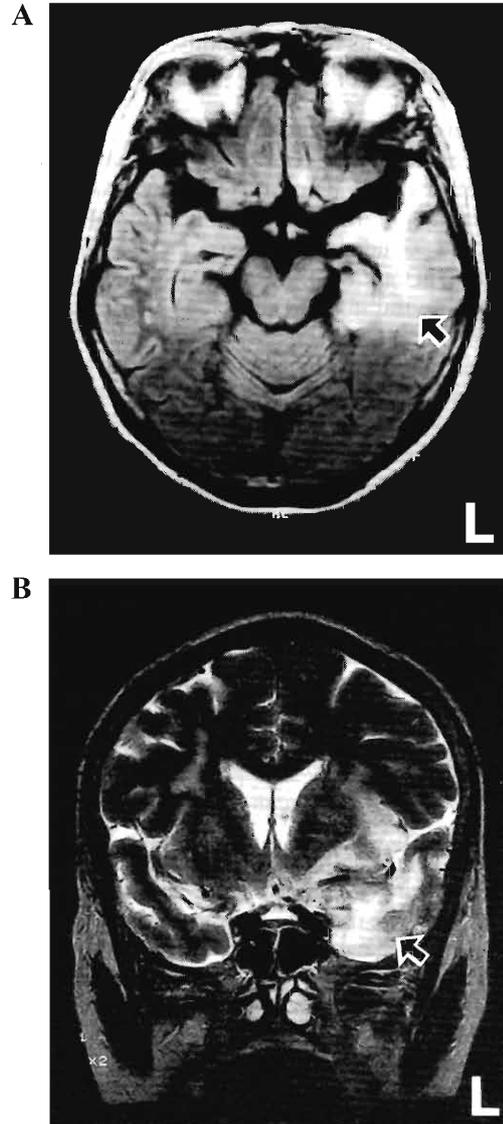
MRI of HSV-1 encephalitis
